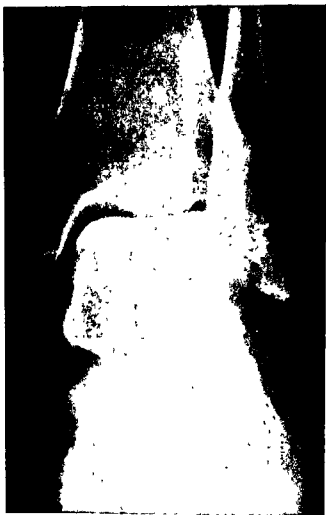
Preoperative roentgenogram showing anteroposterior view of talus with destructive lesion involving most of the bone.
